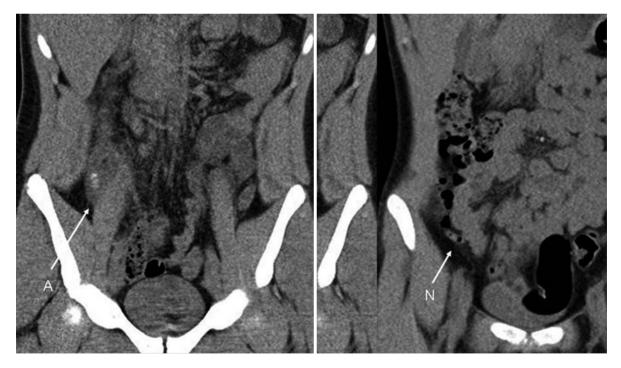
Two patients with suspected appendicitis have undergone a low-dose MDCT of the abdomen and pelvis using an AEC device with the reference image quality effective mAs value set at 50 mAs. The patient on the *left* has a BMI of 24.4 kg/ m^2 , received a dose of 110 mGy·cm and has an acute appendicitis without abscess (*A* and *arrow*). The patient on the *right* has a BMI of 22.1 kg/ m^2 and weighed 70 kg. He received a dose of 73 mGy·cm and had a normal appendix (*N* and *arrow*). The patient on the *left* has a BMI of 28 kg/ m^2 , and weighed 85 kg. He had an acute appendicitis and received a radiation dose of 110 mGy·cm. As in Figure 6.12, the hereby delivered radiation dose represents 20%–25% of the mean reference values from recent CT surveys. This dose is equivalent to the dose of a radiographic examination of the abdomen including three views and is no higher than one-tenth of the reference values for abdomino-pelvic CT scanning
